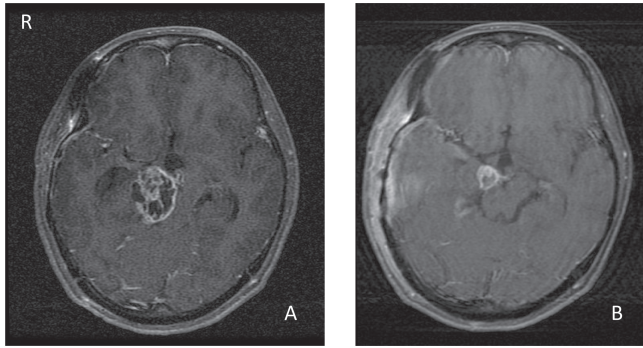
T<sub>1</sub>-weighted with gadolinium magnetic resonance images after the first (A) and second (B) operations showing tumor remains in the oculomotor cistern.
